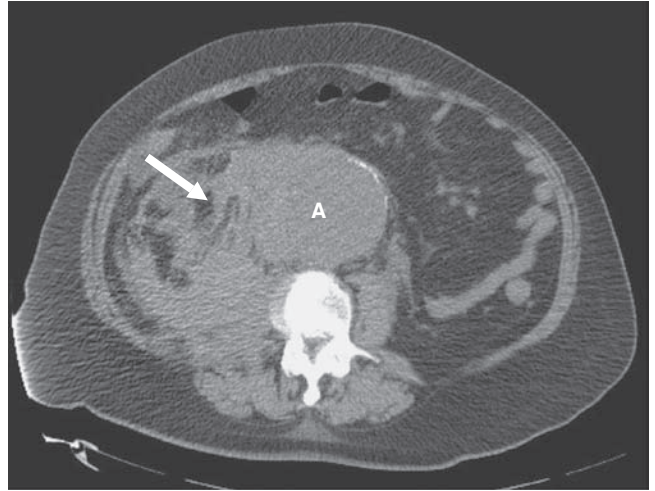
CT scan of ruptured abdominal aortic aneurysm (AAA) with retroperitoneal hematoma.
